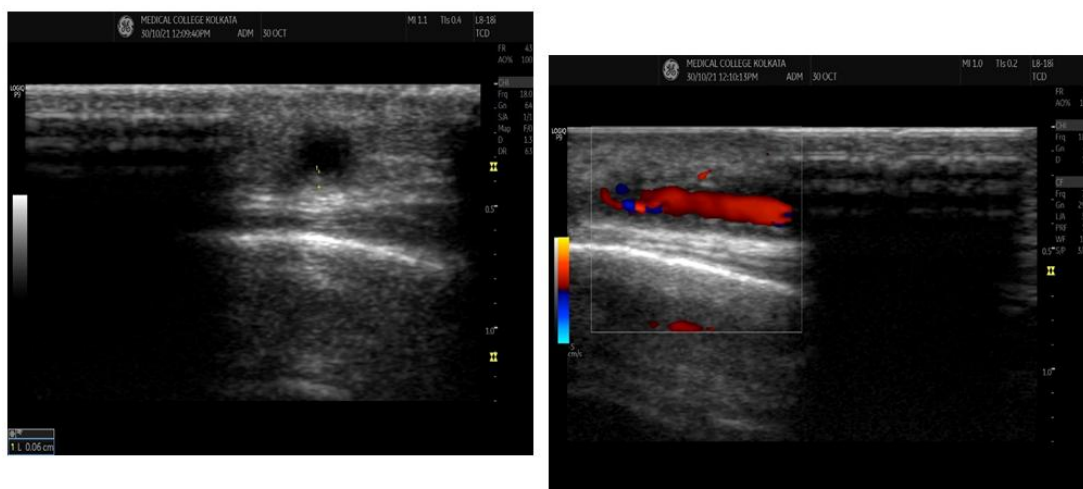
A 55-year-old male presented with severe headache, dimness of vision and jaw claudication. On ultrasound, the frontal part of temporal artery showed a hypoechoic wall thickening with a diameter of up to 0.6 mm around the perfused lumen. Halo score was calculated to be 31 in this patient.
